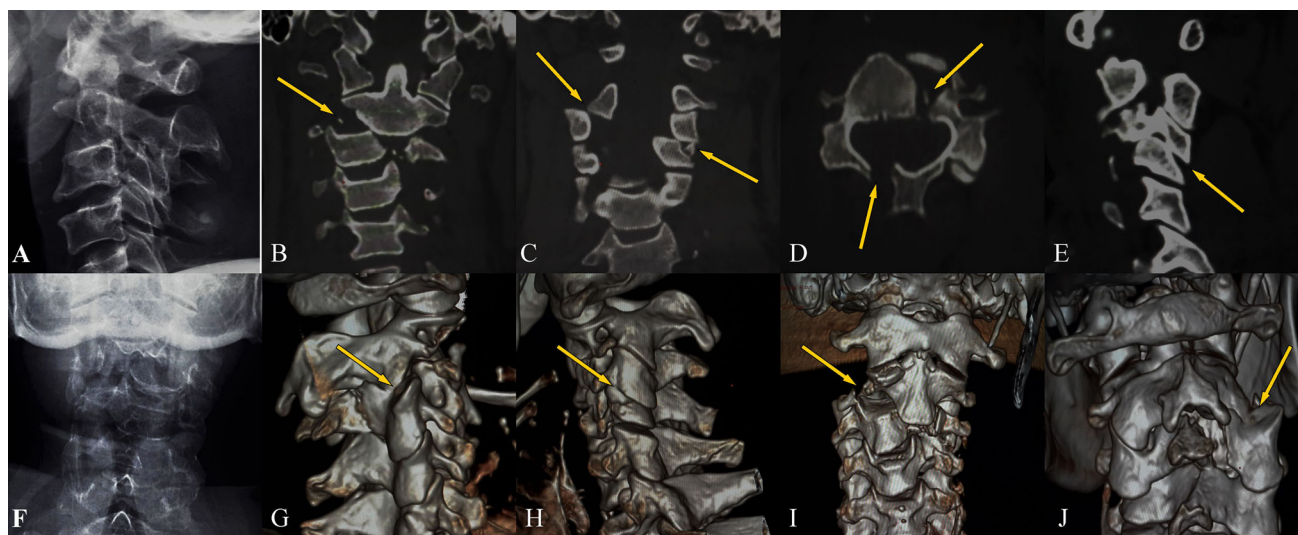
a Preoperative radiology lateral view X-ray showing overlapping C2–3 body confusing it to be fused congenitally, b Coronal view CT showing lateral displacement of C2 over C3 body with mild lateral tilt (arrows in yellow), c coronal CT showing laterally locked C2–3 facets on right side and C3–4 on left side (arrows in yellow), d axial image showing fracture of C3 lamina on right side and body pedicle junction on left side (arrows in yellow), e parasagittal CT
